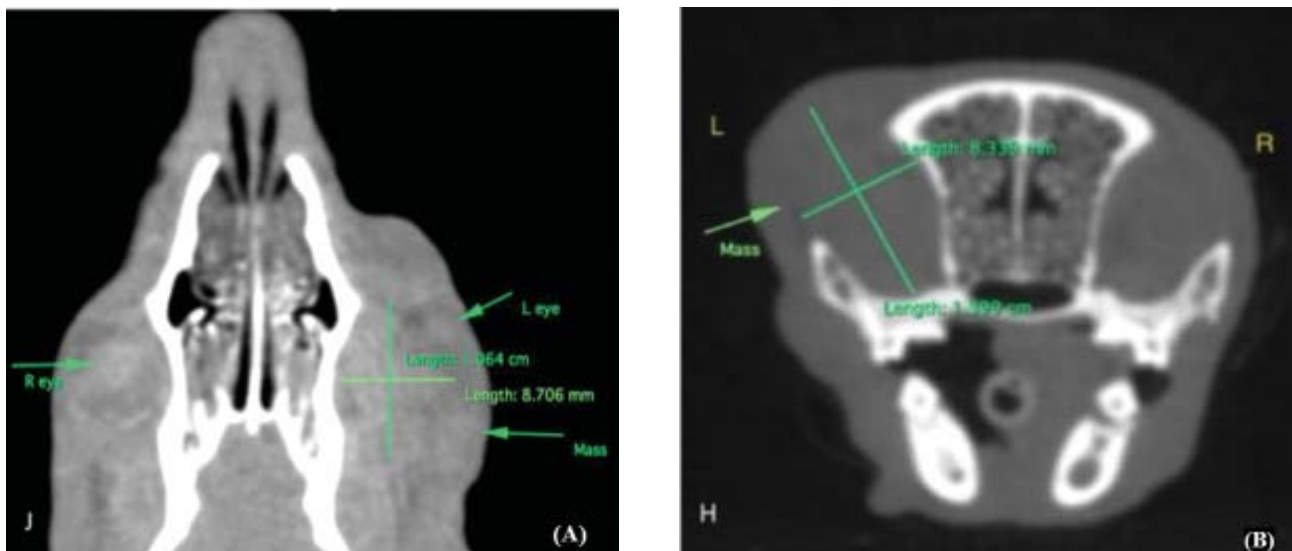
Soft tissue window of dorsal view skull CT scan showed left eyelid mass extended into the left retro bulbar region caused the left ocular compression and exophthalmos. Small size of left ocular (smaller compared to the right ocular). No evidence of bone reaction and bone destruction was detected. Mild reactive of left medial retropharyngeal lymph node (regional lymph node) (A). The same mass in transverse view skull CT scan (B).
